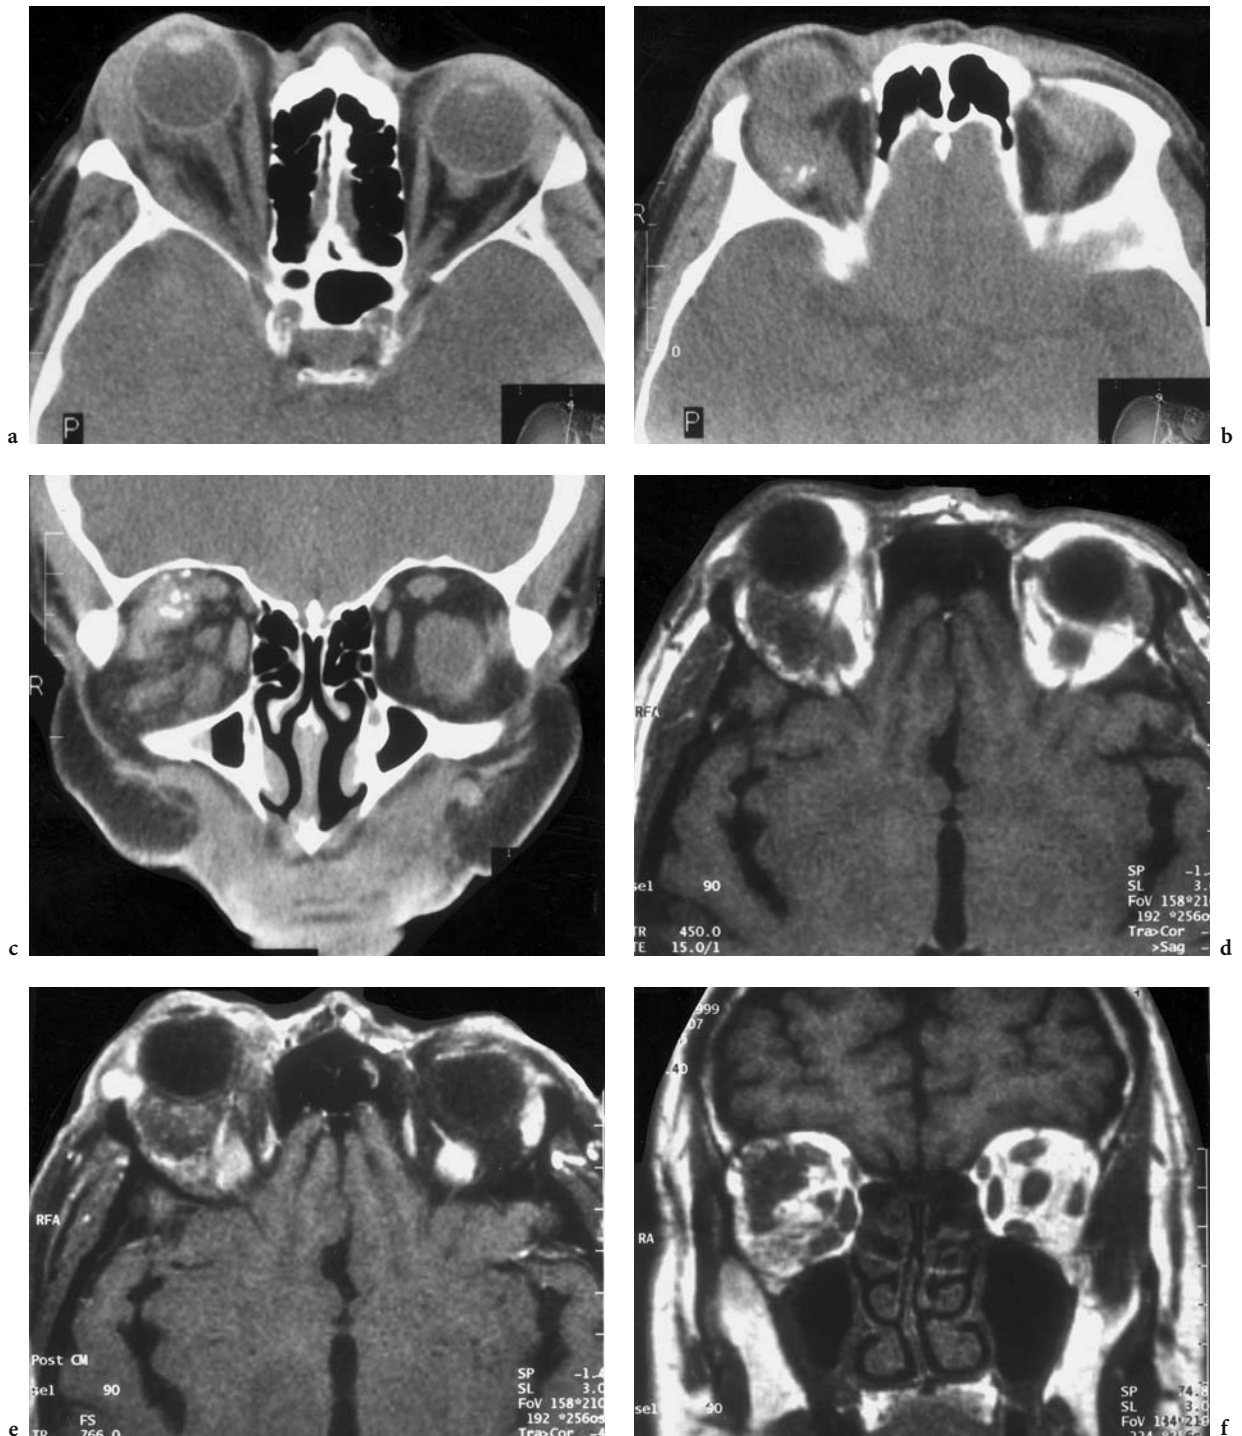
A 71-year-old man with persistent, slowly progressing, right-sided proptosis, but an acute history of ipsilateral painful chemosis. Diagnosis: orbital amyloidoma. CT: a Axial native view where medial of the orbit, in addition to exophthalmos of the right eye and extraconal location of the slightly enlarged lacrimal gland, an irregular contour of the lateral rectus muscle and adjacent bulbar fat can be identified. b Axial native view of the superior orbit which is characterized by an irregular, partly calcified mass. c Coronal view of the middle orbit, demonstrating the partly calcified intraconal mass between the lateral and superior rectus muscle. MRI: d Axial T1-weighted native view, corresponding to b. Note the small, normal superior ophthalmic vein in both images. e Corresponding contrast-enhanced (FS) view without marked contrast enhancement of the mass. f Coronal T1-weighted view (corresponding to c) with suspicion of additional extraconal involvement
